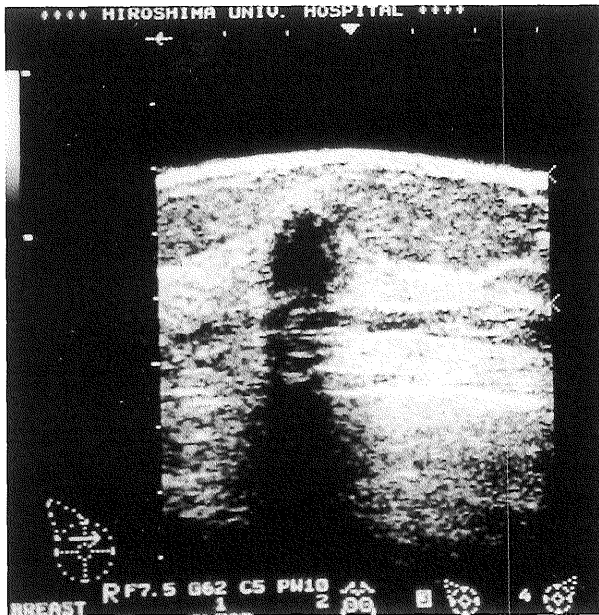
Ultrasonography showed a hypoechoic mass with an irregular border.
